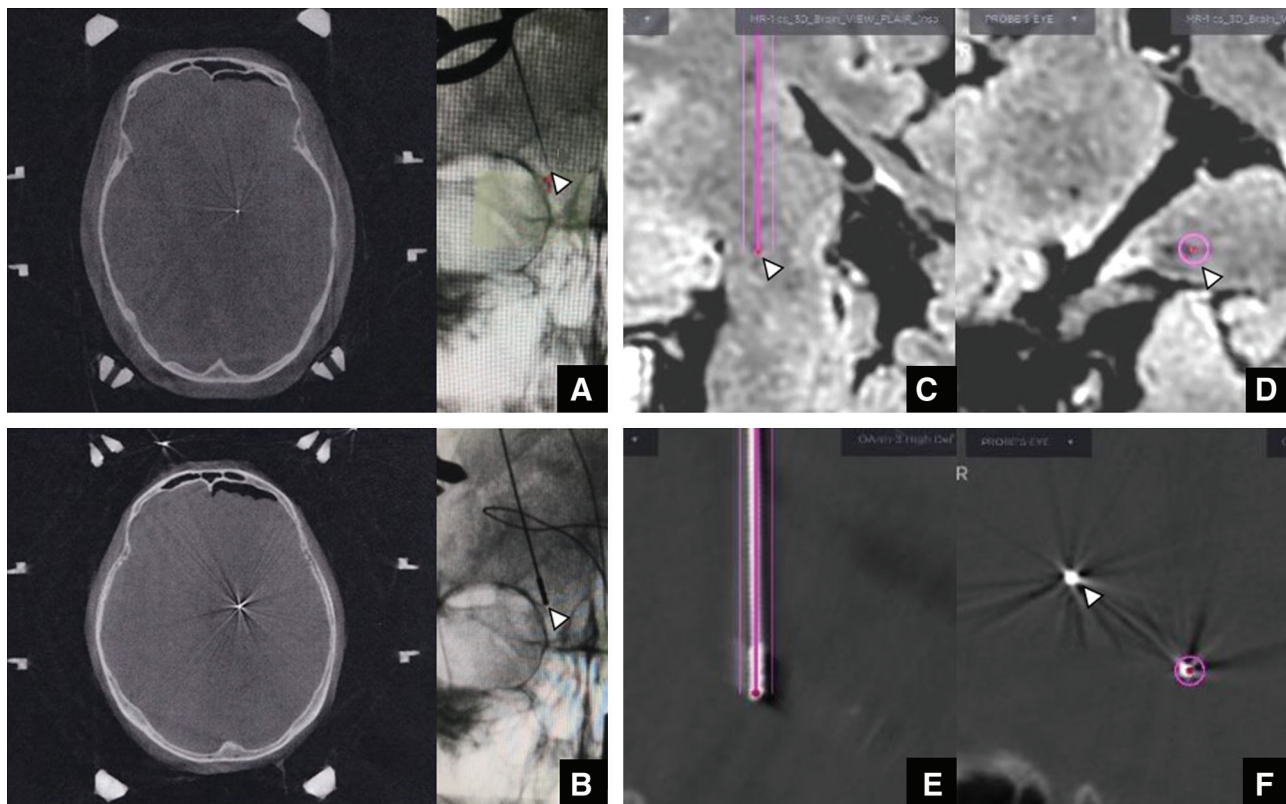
The view of intraoperative imaging and confirmation of the lead position on surgical planning. (A) Microelectrode placement on 3D CT and 2D fluoroscopy images by O-arm. (B) Lead placement on 3D CT and 2D fluoroscopy images by O-arm. On the 2D fluoroscopy image, positions of the microelectrode and lead (arrowhead) coincide. (C, D) Surgical planning for the target (arrowhead) on MRI on the platform with the same coordinate system as computed tomography (CT by O-arm) images. (E, F) Images from 3D CT by O-arm of the inserted lead (thick white line) in two different axes on the platform with the same coordinate system as the MRI. The pink line shows the surgical plan. The lead can be seen to be inserted toward the target following the surgical plan shown by the pink line. In (F), the DBS electrode already inserted at the target on the opposite side is also visible in the same slice (arrowhead).
